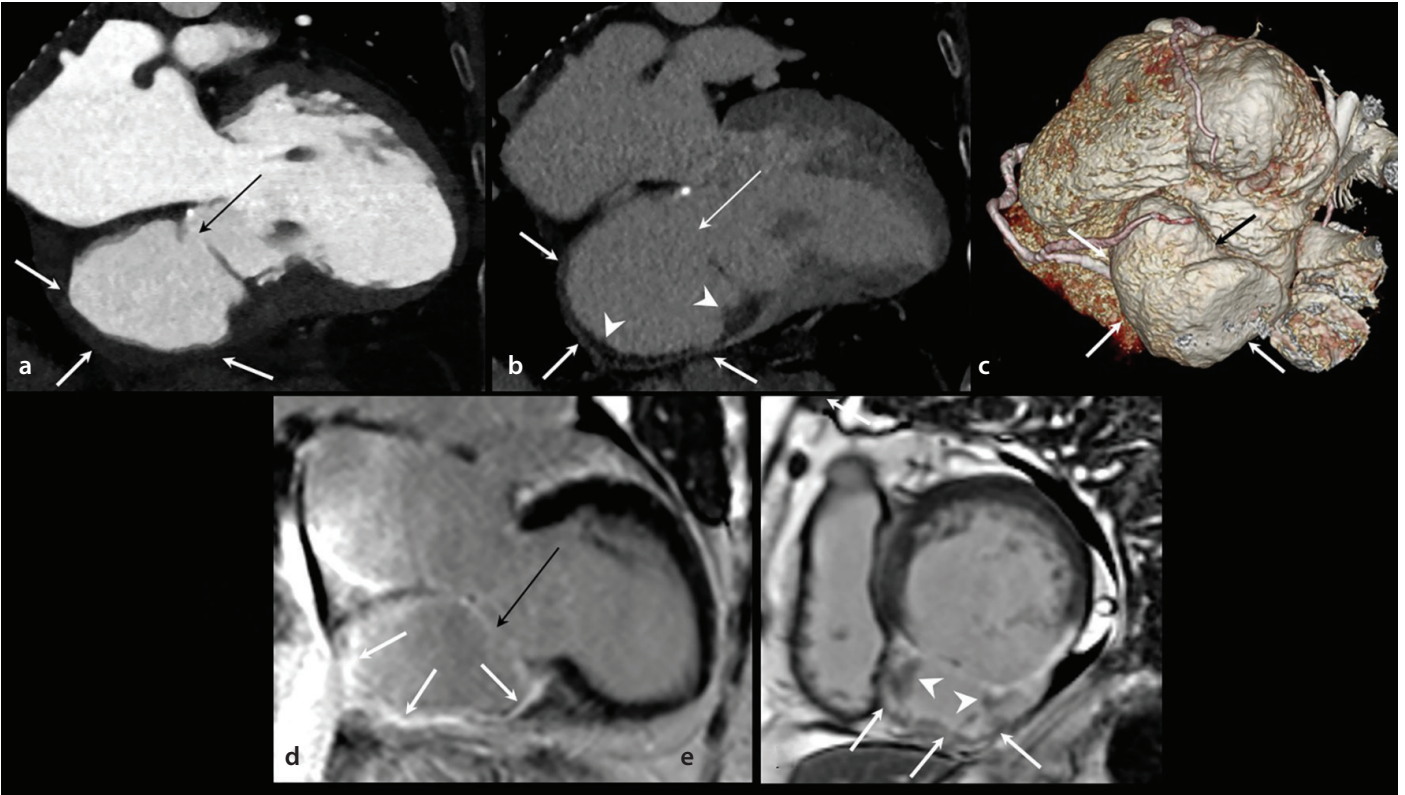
Left ventricular pseudoaneurysm in an 80-year-old woman with a history of reperfused STEMI. (a, b): Two-chamber MPR early contrast-enhanced (a) and MDE (b) CT images demonstrate a pseudoaneurysm of the basal to mid-inferior wall of the left ventricle with a narrow neck (long arrow), very thin wall (arrows), and intracavitary thrombus (arrowheads). (c): Three-dimensional, volume-rendering CT image of the heart shows a large aneurysm (arrows) arising from the inferior wall of the left ventricle. (d, e): Two-chamber (d) and short-axis (e) LGE-CMR images demonstrate a large inferior pseudoaneurysm with a narrow neck (d, long arrow), diffuse LGE of the pseudoaneurysm wall (arrows), and a thrombus (e, arrowheads). The surgical finding was consistent with a pseudoaneurysm caused by a rupture of the LV wall secondary to MI. STEMI, ST-segment elevation myocardial infarction; LV, left ventricular; MPR, multiplanar reformation; CMR, cardiac magnetic resonance; CT, computed tomography; LGE, late gadolinium enhancement; MDE, myocardial delayed enhancement.
